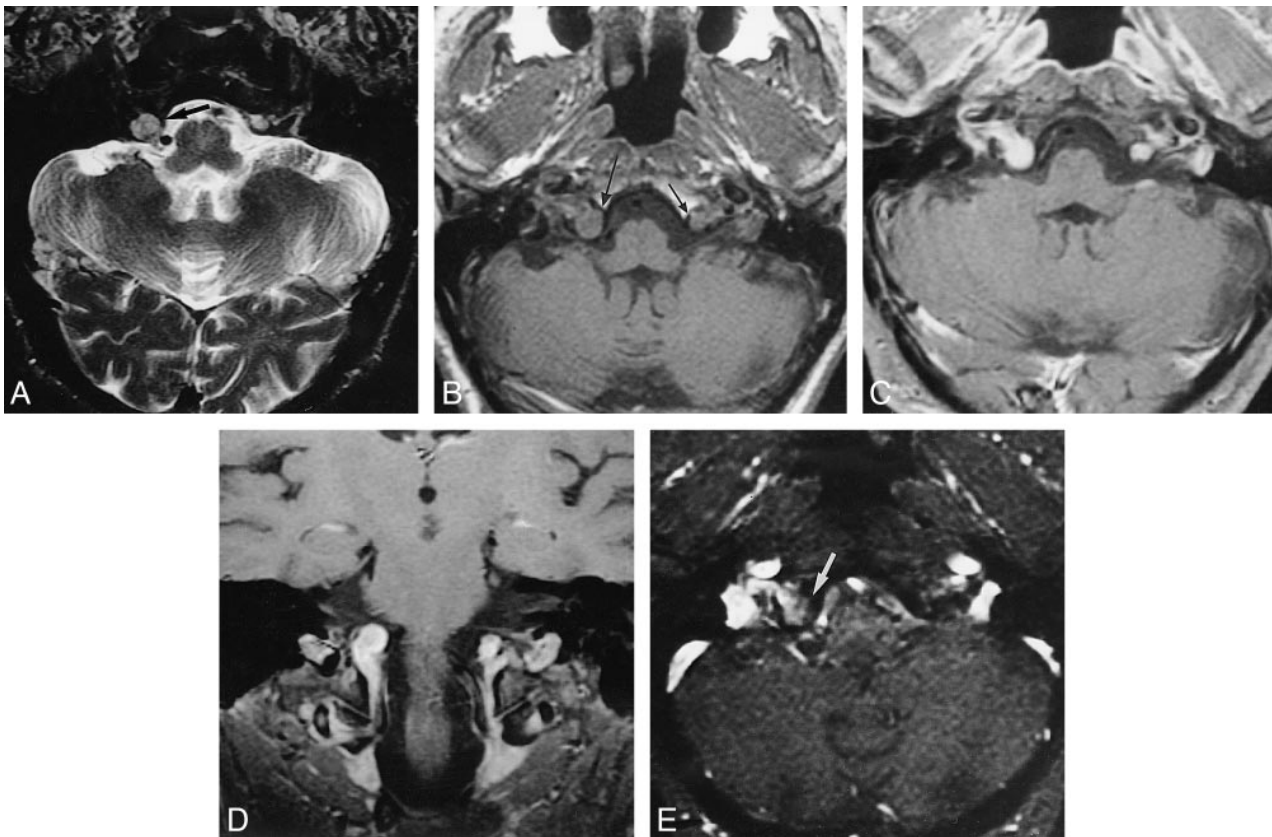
MR imaging findings in a 54-year-old man with a history of possible temporal lobe epilepsy.
